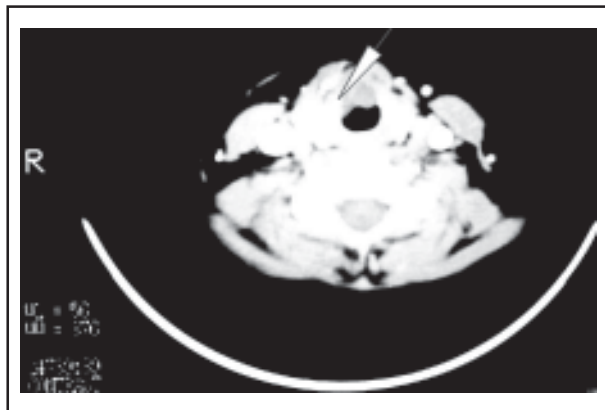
& Fig-2: Computed tomography (CT) scan of thorax revealed enhancing lesion at the right subglottic region measuring 1.1cm x 1.3cm
